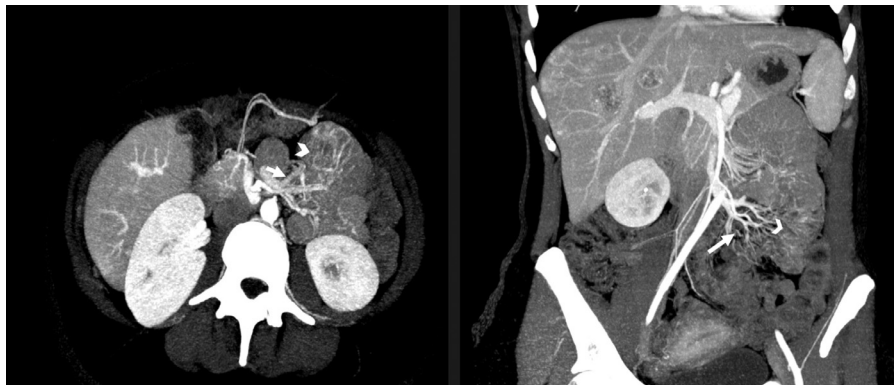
Neoplastic angiodyplasia MPR and MIP reconstruction. Axial (on the left) and sagittal (on the right) contrast-enhanced CT images, arterial-phase, MPR and MIP reconstruction, show inhomogeneous focal areas of increased enhancement in bowel wall (arrowhead) with swollen and hypertrophic intramural vessels, with earlier filling of enlarged antimesenteric veins (arrow), typical sign of indicating arteriovenous shunting, better visualized due to using Maximum Intensity Projection (MIP) and Multi-Planar Reconstruction (MPR) post-processing. These findings are typical of neoplastic angiodyplasia.
